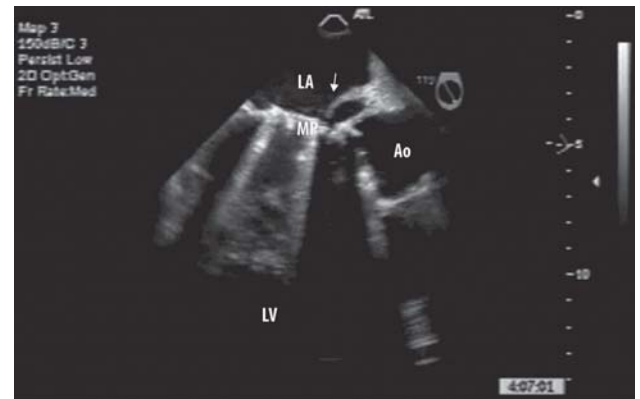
Transesophageal echocardiogram showing an abscess evolving into an aneurysm in the mitral-aortic intervalvular fibrosa
